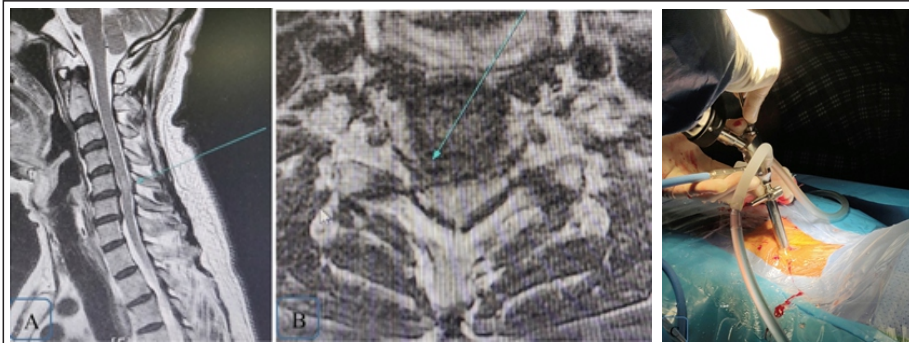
Sagittal (a) and (b) axial MRI images of a 36-year-old male who presented with the right upper limb radiculopathy show discogenic compression. The patient was managed with uniportal posterior endoscopic decompression ©.
